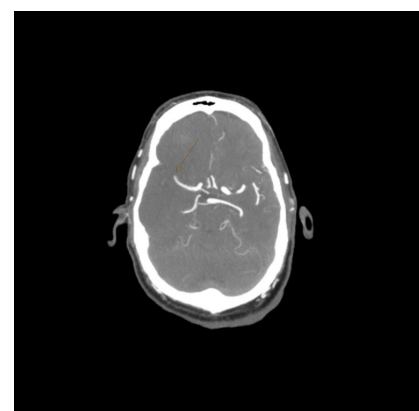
CTA showing abrupt cutoff of the right MCA at the bifurcation, representing an acute MCA occlusion.
